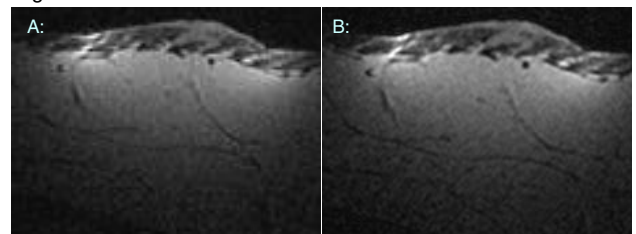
In vivo MRI of the birthmark using the surface coil. T1-weighted 3D spoiled gradient-echo ($200 \times 200 \times 340 \mu\text{m}^3$):
